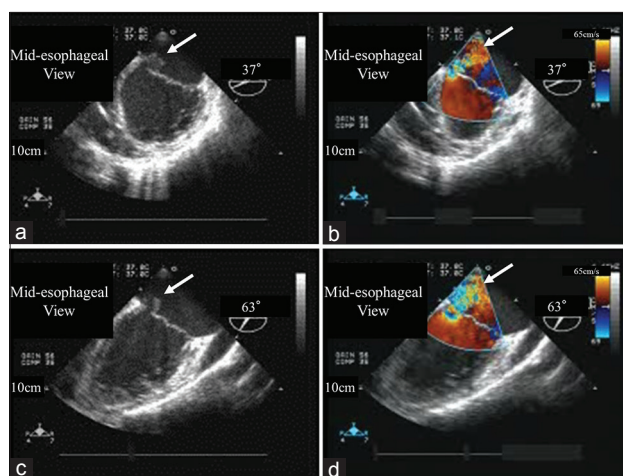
Transesophageal echocardiography in the mid-esophageal view. Severe mitral valve regurgitation and rupture of the chordae tendineae of the A3 segment of the anterior mitral valve leaflet (Figure 1-a-b, at 37°; Figure 1-c-d, at 63°)
